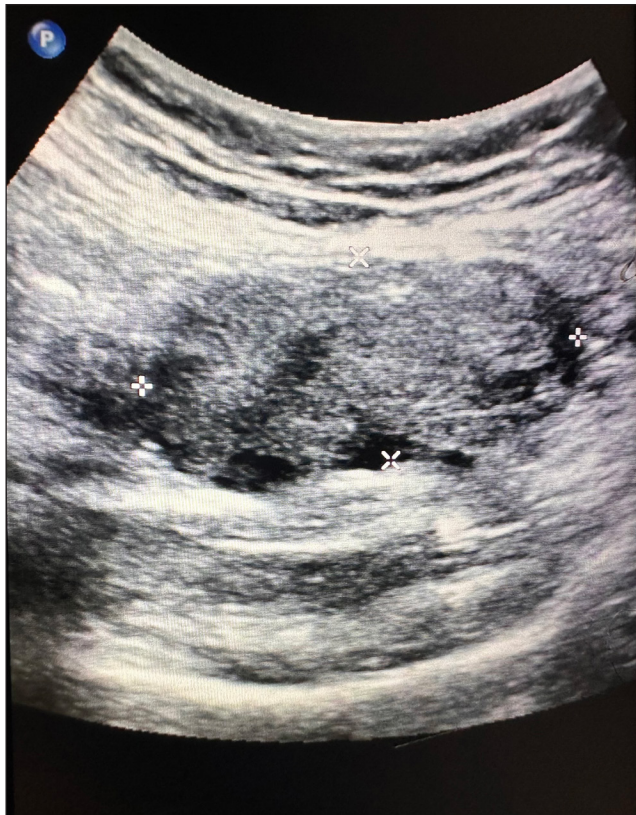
On ultrasound: diffusely bulky, edematous left ovary with peripherally placed follicles.
